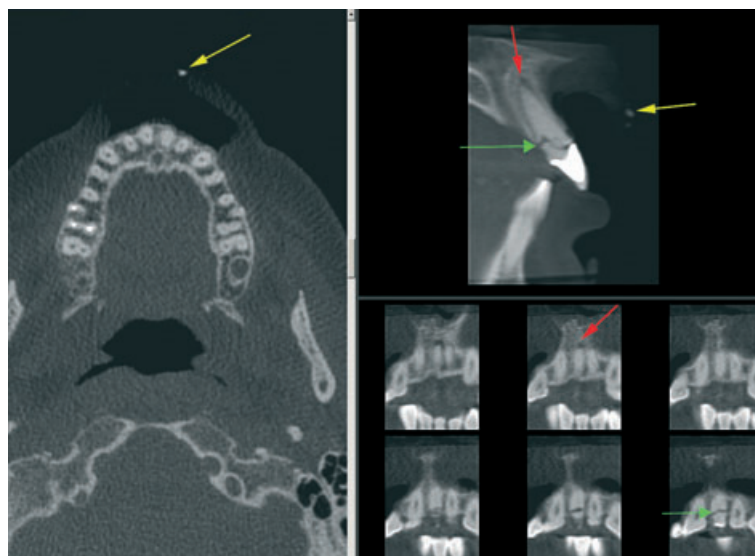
A single CBCT scan used in the management of a luxation injury. The axial (left) and sagittal (top right) views reveal the presence and exact location of the fractured portion of the crown fragment (yellow arrow) in the upper lip, the scan also reveals an oblique fracture of tooth 21 (green arrow) and widened labial apical-third periodontal space as a result of a lateral luxation injury (red arrow).
